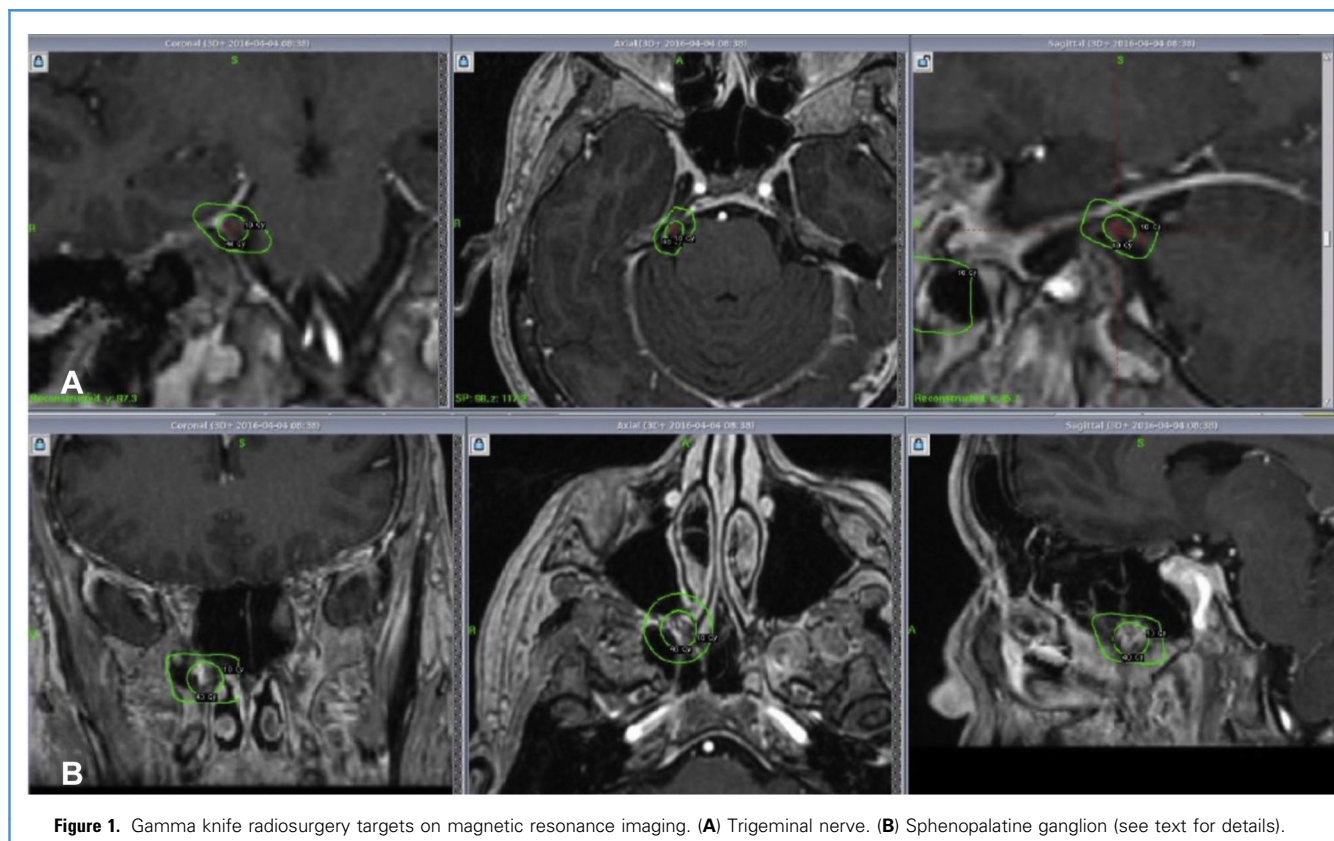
Gamma knife radiosurgery targets on magnetic resonance imaging. (A) Trigeminal nerve. (B) Sphenopalatine ganglion (see text for details).
